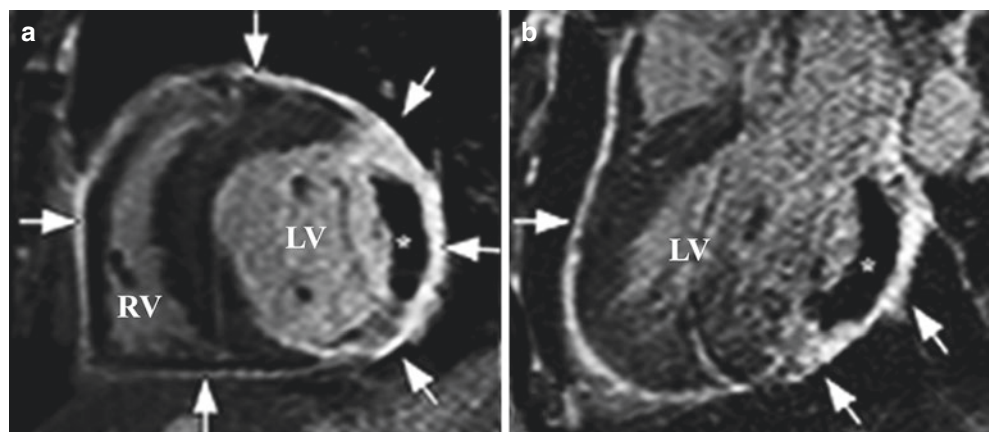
Acute pericarditis T1-weighted spin-echo images (a, b) in axial and short axis views of a 37-year-old woman with rheumatoid arthritis presenting with acute chest pain, demonstrating moderate-sized pericardial effusion (asterisks). Matching LGE images (c, d)
